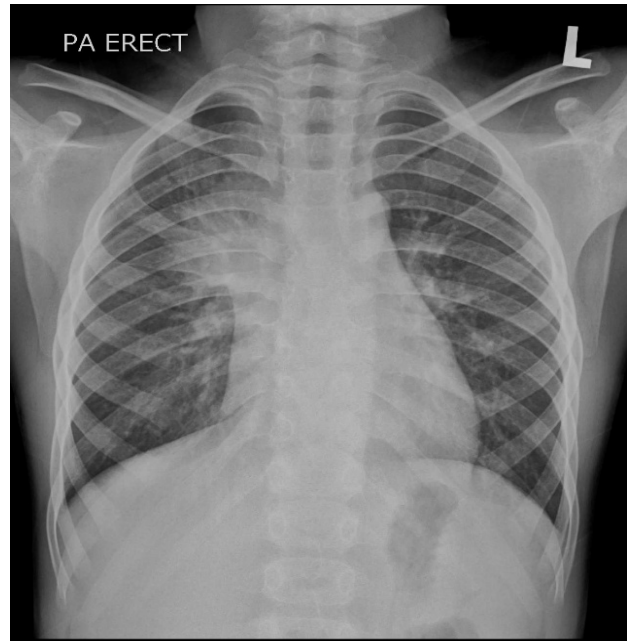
A follow-up chest radiograph after completion of one year of antituberculosis treatment, shows improvement of right upper lobe consolidation.
